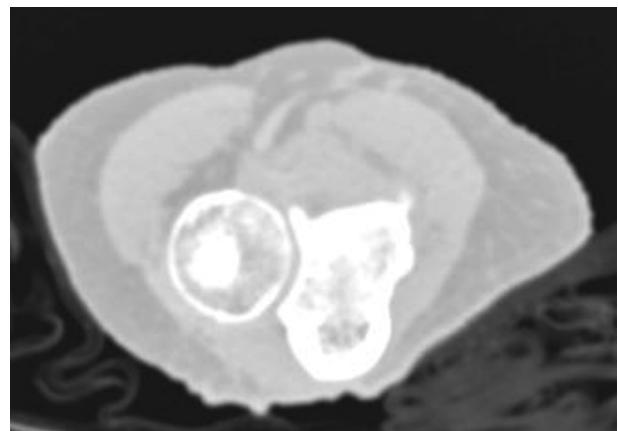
Axial CT cut of the proximal radioulnar joint with the lung viewing window. No intra-articular air is noted. *CT*, computed tomography.
